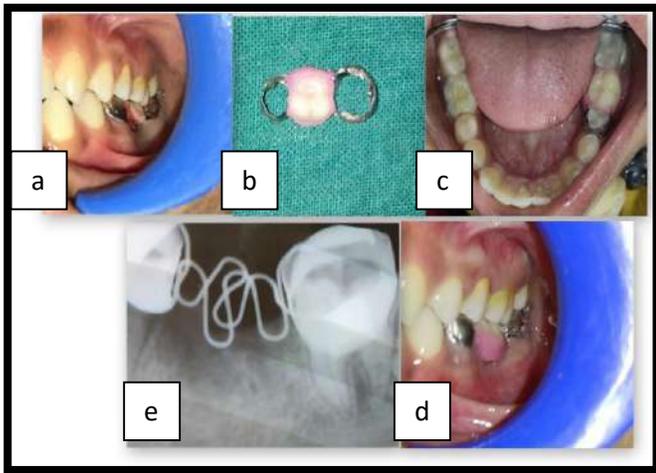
Final Occlusion and radiograph
